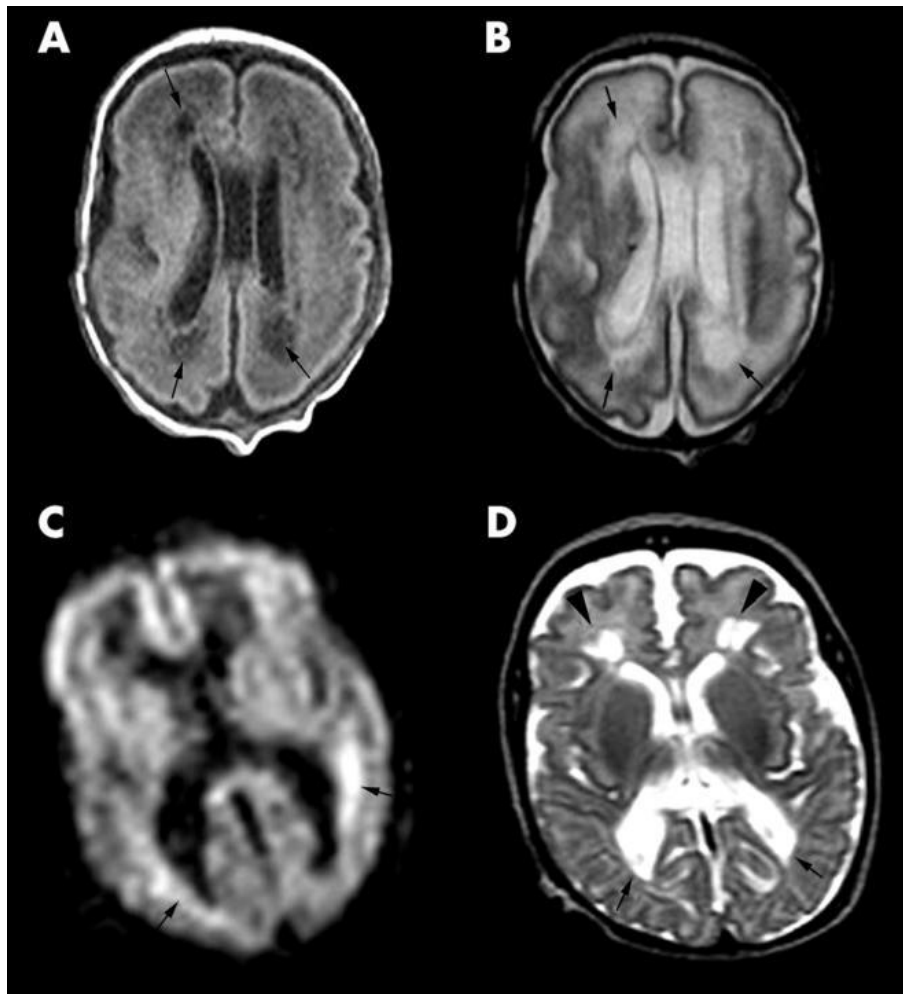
MRI image showing a characteristic form of injury of the premature brain, *periventricular leukomalacia (PVL)*. Image was published by Counsell et al. (19), with the following figure legend: *PVL in an infant at 28 weeks gestational age. (A) Transverse T1 weighted image at the mid-ventricular level showing cystic PVL as areas of low signal within the cerebral white matter posterior and anterior to the lateral ventricles (arrows). (B) Transverse T2 weighted FSE image at the mid-ventricular level showing the cystic lesions as high signal intensity (arrows). (C) DWI image showing areas of restricted diffusion around the lateral ventricles as high signal intensity (arrows). (D) T2 weighted FSE image of the same infant at 40 weeks GA showing squared off posterior horns of the lateral ventricles (arrows) and diminished white matter posteriorly. Cystic lesions are shown anterior to the anterior horns of the lateral ventricles (arrowheads)*
